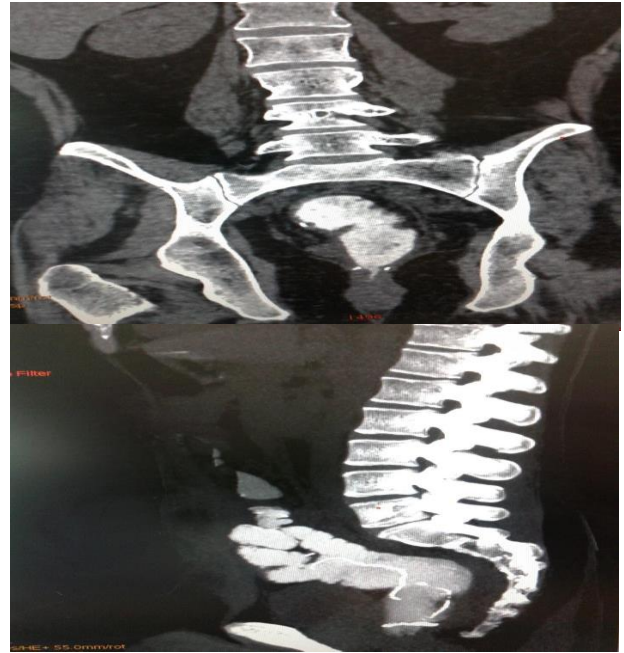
CT Pouchogram showing healthy ileal pouch anal anastomosis before reconstruction of bowel of diverting loop ileostomy.
